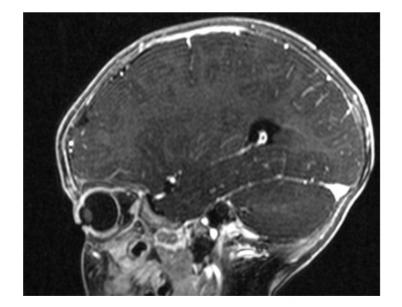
T1-weighted MRI after the administration of paramagnetic contrast in a sagittal view demonstrates enhacement and thickening of the pachymeningeal lining adjacent to the colletion site
